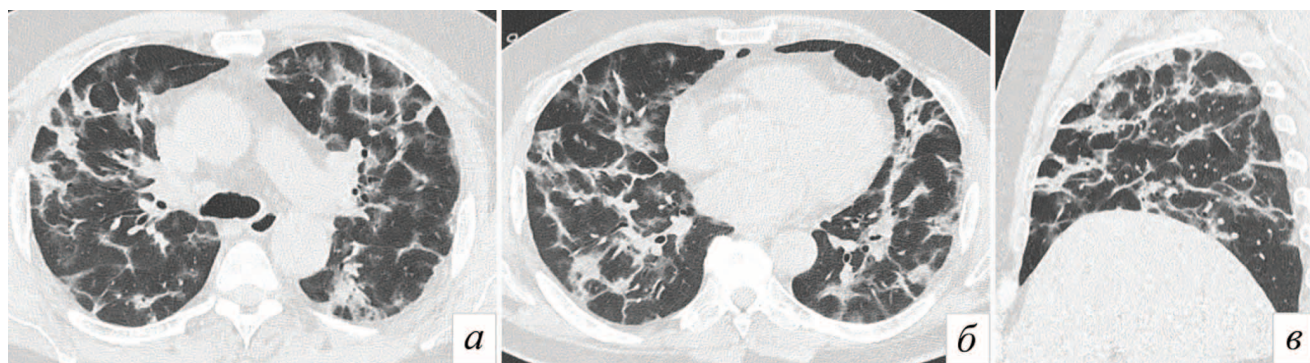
Patient K, 55 years old. The early resolution phase of lung injury in COVID-19. Thoracic CT scans in axial (a, b) and sagittal (c) projections. Multiple band-like strips of consolidation, perilobular hardenings. This CT picture is presented by the pattern of OP in combination with discoid atelectasis, which can be mistaken for fibrotic changes
